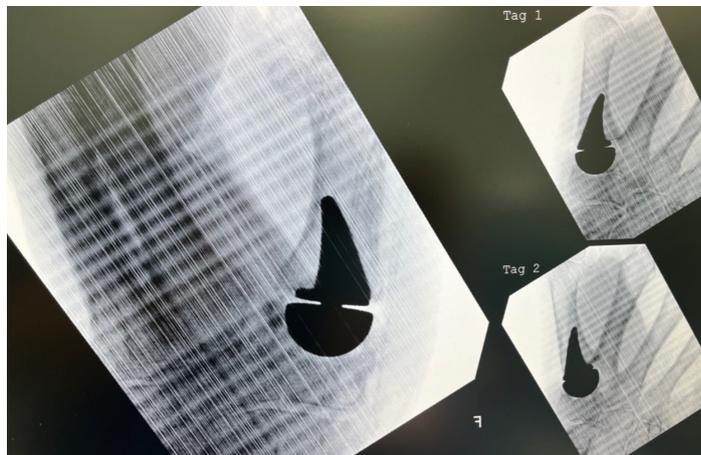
Intraoperative radiographs showing implant position and the inbuilt varus attitude of the metacarpal prosthesis to adduct the thumb metacarpal.
